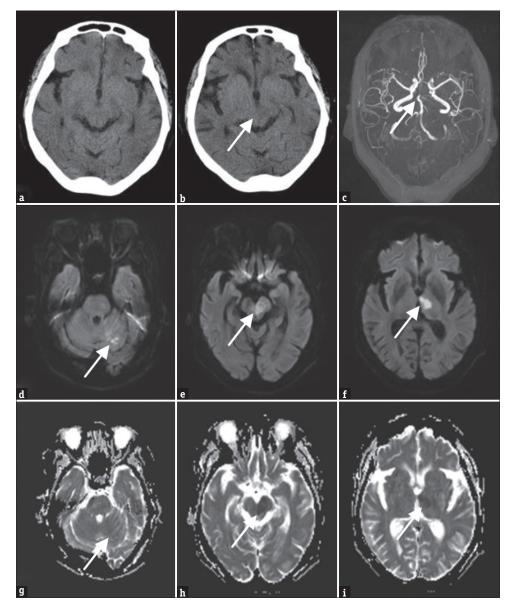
(a) No obvious abnormality was found on head CT before the onset of the disease. (b-i) Brain infarction signals can be observed on head CT, magnetic resonance angiography, and magnetic resonance imaging at the time of stroke onset
